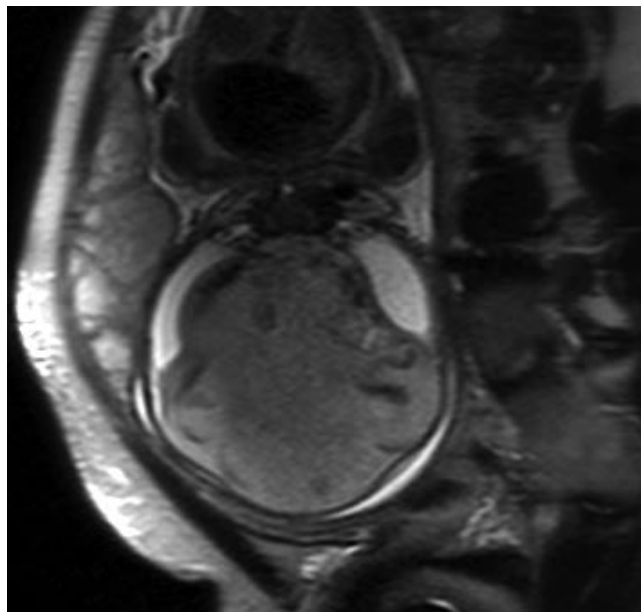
Prenatal MRI demonstrating large intra-cranial haemorrhage.
